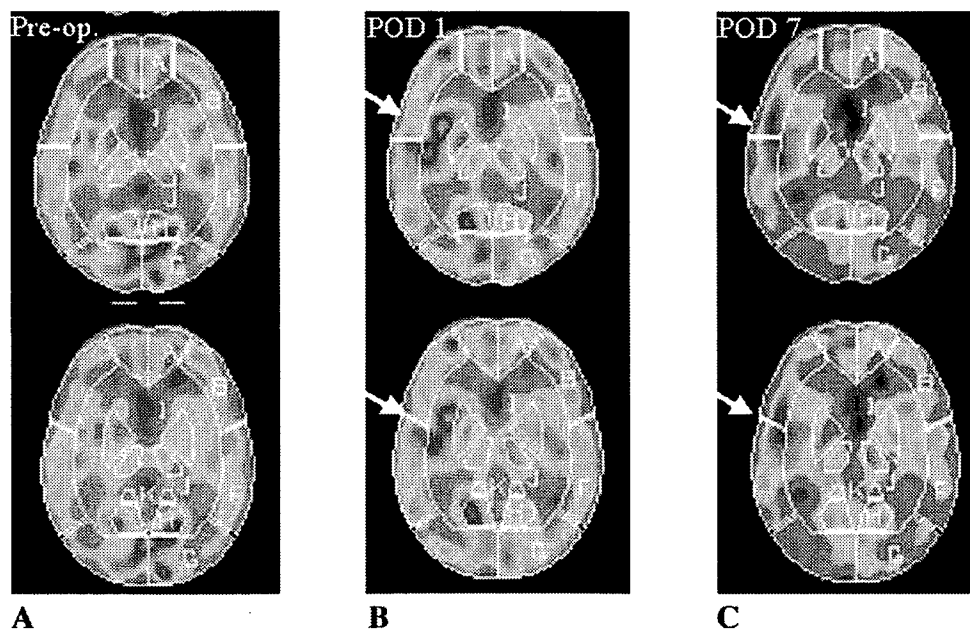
Case 8. ^{123}I -IMP-SPECT scans before surgery (A) and 1 (B) and 7 days (C) after surgery. Significant increase in CBF was detected on the side of anastomosis 1 day after surgery (arrows in B). The increase in CBF was sustained (arrows in C) 7 days after surgery.
